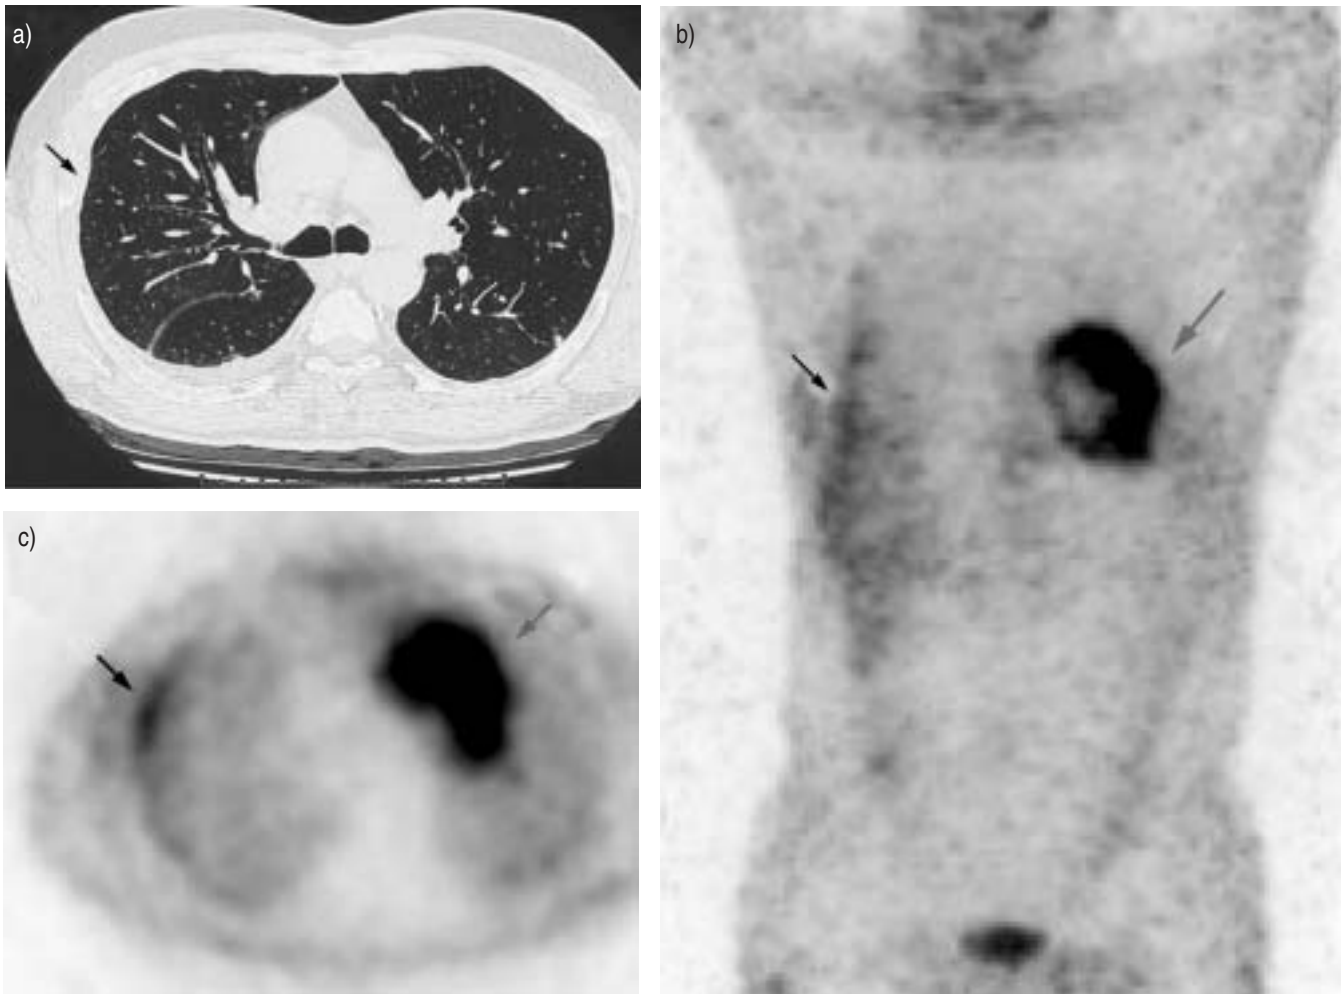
A 56-yr-old patient with pleural effusion. a) Computed tomography scan confirmed a right moderate pleural thickening (arrow). b) Three-dimensional imaging in maximum pixel raytrace in the anterior view showed localised increased of ^{18}F FDG uptake on right parietal pleura (arrow) and physiological uptake of ^{18}F FDG by the myocardium (grey arrow). c) Transverse ^{18}F -fluorodeoxyglucose (^{18}F FDG) imaging *via* coincidence detection emission tomography demonstrated localised pleural increase of tracer (arrow). There is physiological uptake of ^{18}F FDG by the myocardium (grey arrow).
